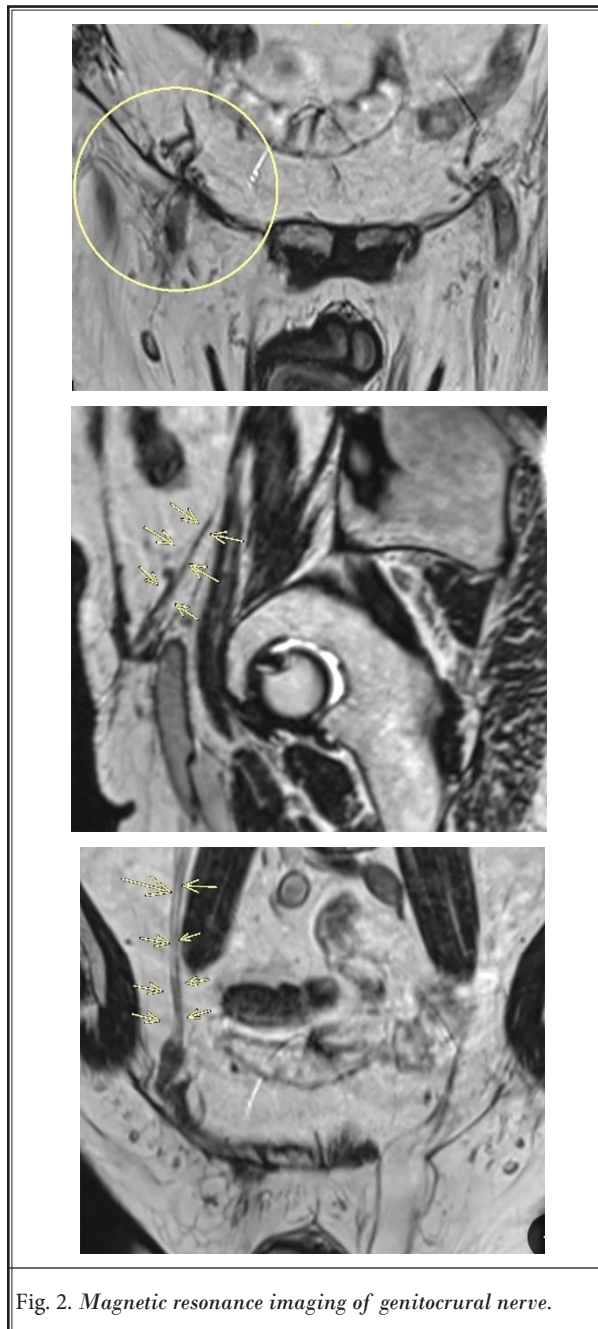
Magnetic resonance imaging of genitocrural nerve.
